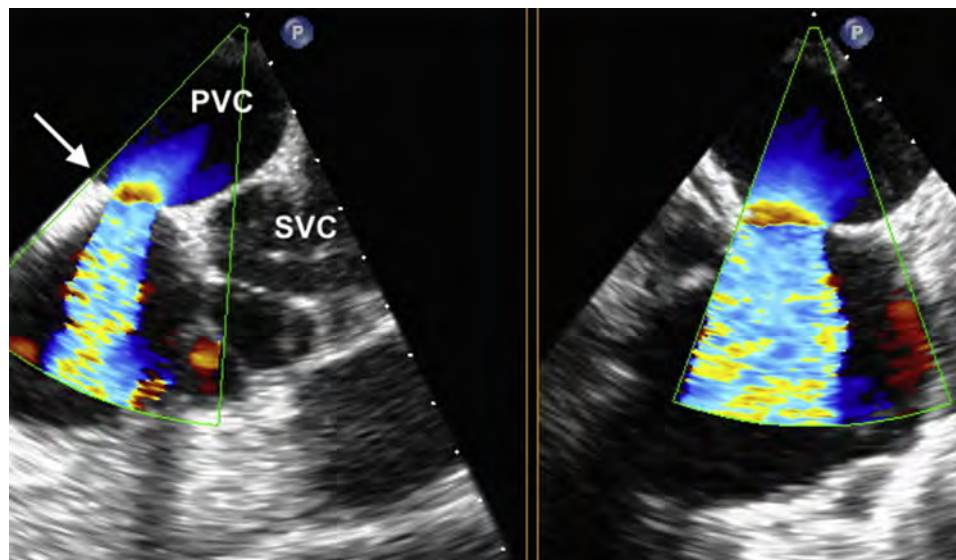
TEE in a biplane view (at 80° and 26°) using color Doppler in an adult patient who has had an AtrSO demonstrating acceleration of flow in the pulmonary venous channel (*white arrow*) (PVC). Note the relationship of the systemic venous channel (SVC) (with a pacing wire seen in the channel) to the pulmonary venous channel, which wraps around it.
